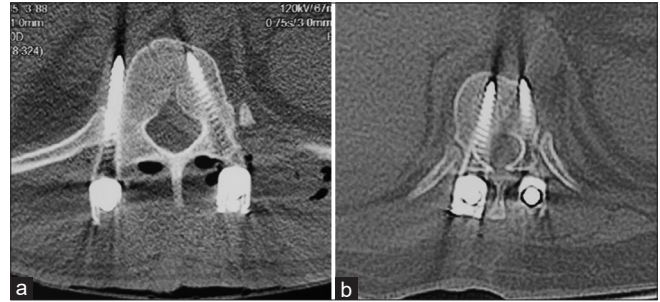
Postoperative CT 3D axial views to document a lateral breach of the right-sided screw (a) and a medial breach of the right-sided screw (b).
